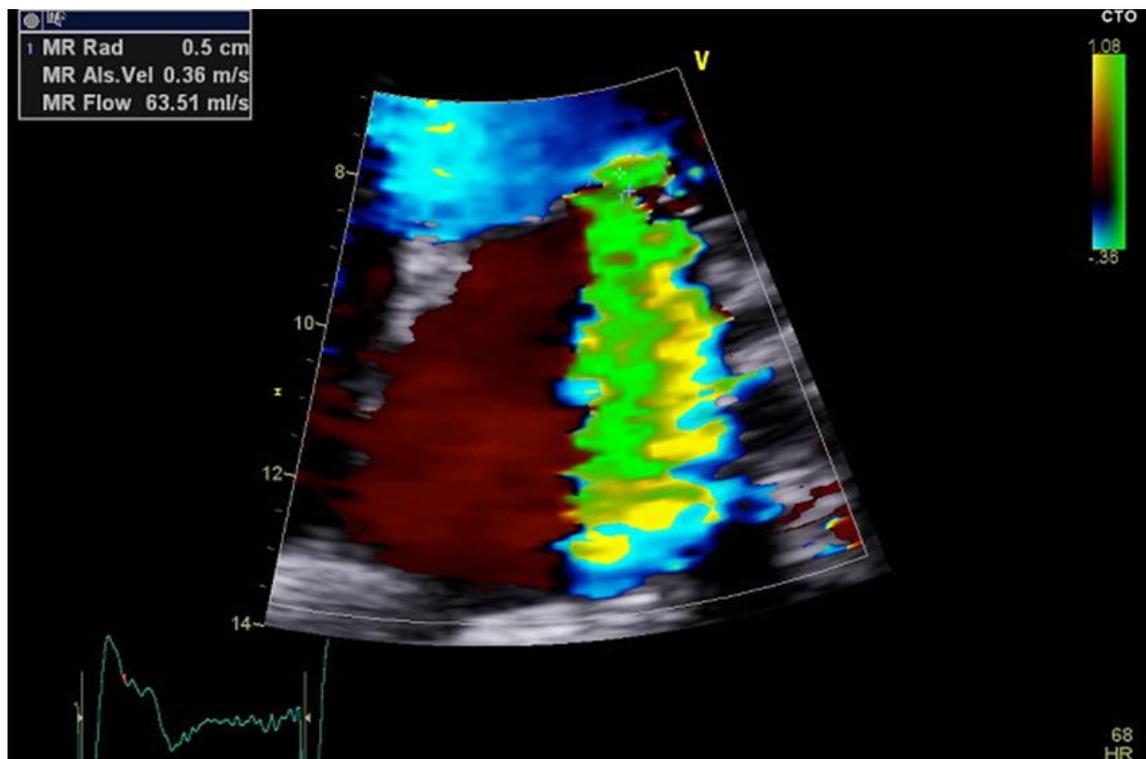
Colour Doppler demonstrating a moderate jet of mitral regurgitation in the apical 4-chamber view
